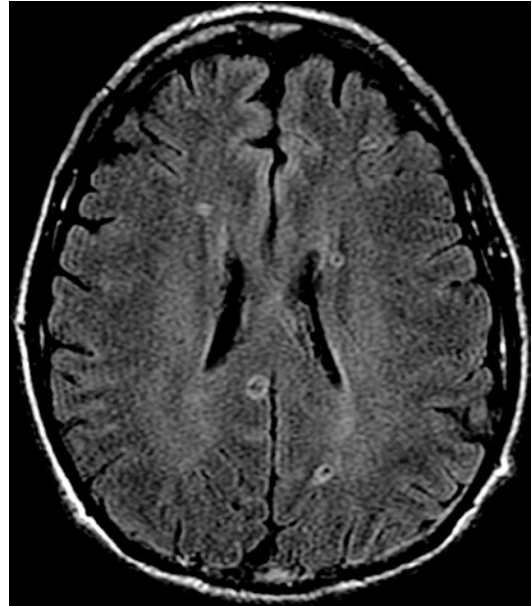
Axial FLAIR brain MR of a 61-year-old Ecuadorian male demonstrates thin-walled cysts, one of which has a mural nodule. This is the vesicular stage of neurocysticercosis. (Image courtesy of Kevin Spittler, MD)
